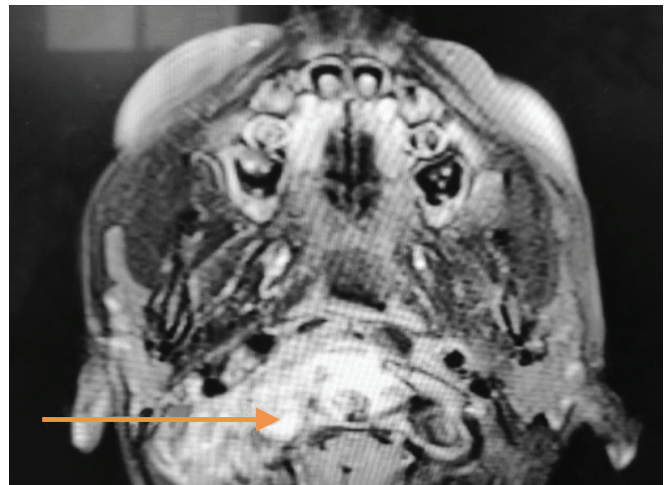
Post contrast CT enhancement (temporal view) showing retropharyngeal abscess
